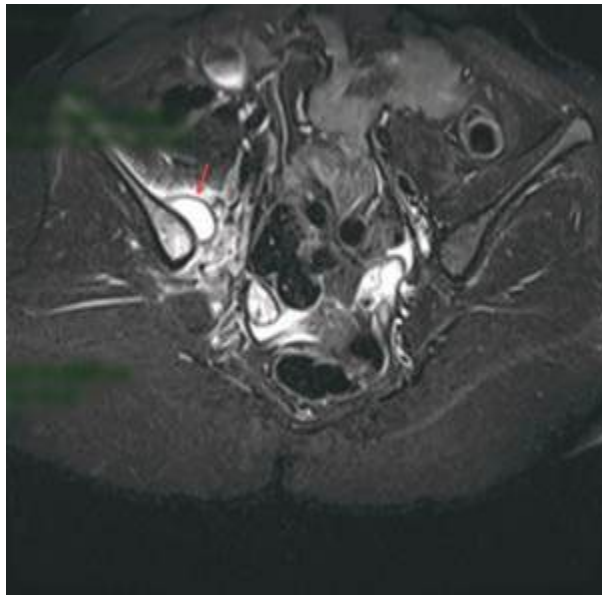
Coronal T2-weighted MRI showing a well-defined hyperintense fluid collection adjacent to the right sacroiliac joint with surrounding inflammatory changes extending into the iliopsoas region, consistent with an iliopsoas abscess (arrow).
